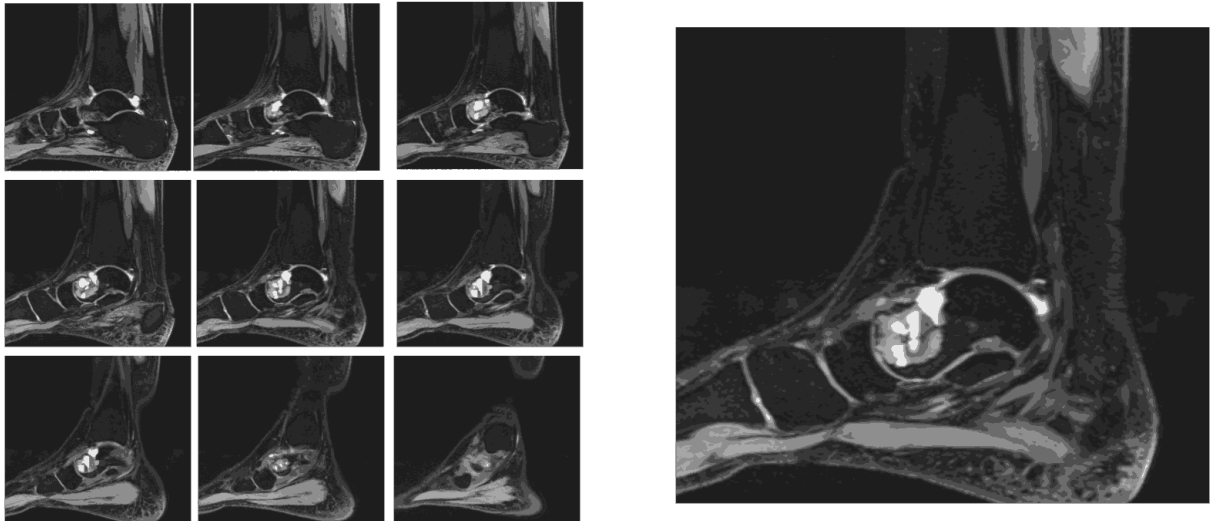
Right Ankle MRI T2W Sagittal View.
